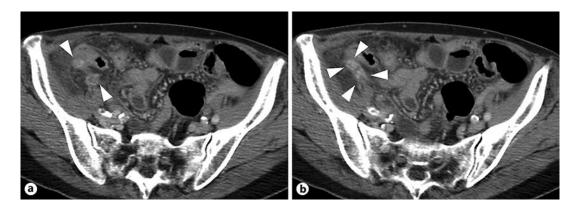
a, b Computed tomography revealed an enlarged appendix, appendiceal wall enhancement, and periappendiceal fat stranding.
